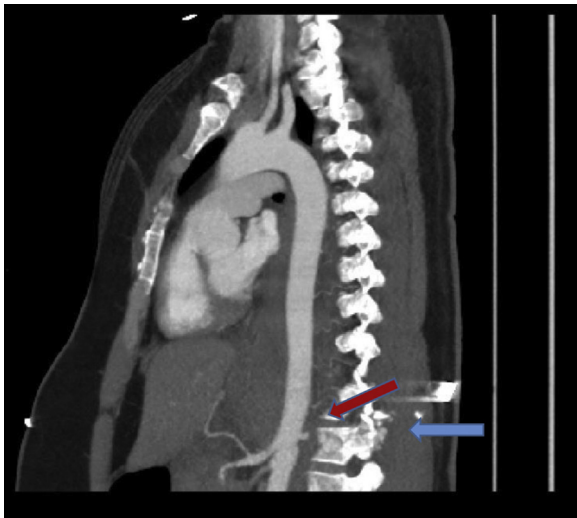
Computed tomography (CT) scan before intervention. The *blue arrow* marks the thoracic body fracture; the *red arrow* marks aortic extravasation.
